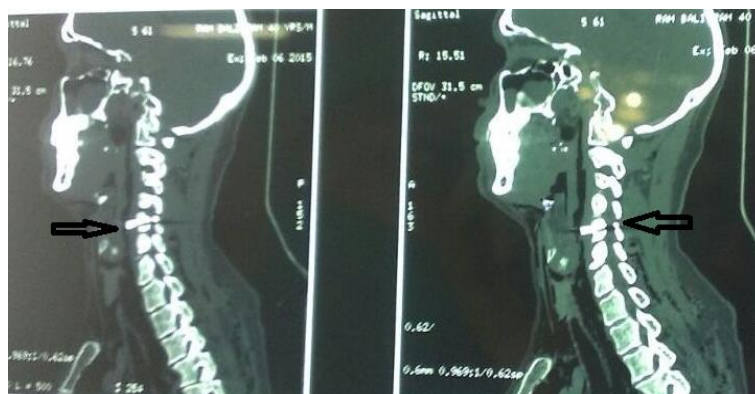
Computed tomography (CT) picture showing foreign body embedded in C5 vertebra
